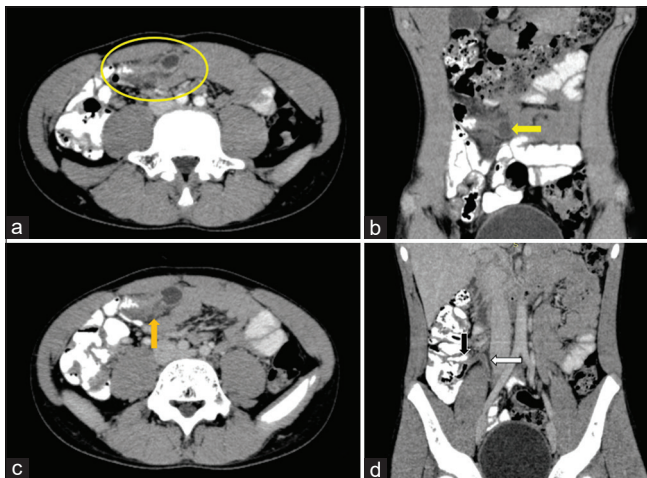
Axial and coronal reformatted images of contrast-enhanced Computed Tomography with positive oral contrast of the abdomen of the same patient show (a) an inflamed Meckel's diverticulum with surrounding fat stranding and collection at its apex (area within yellow oval), (b) the origin of the diverticulum from the antimesenteric aspect of the ileum (yellow arrow), (c) shows a focal breach in its posterior wall (orange arrow), and (d) shows a normal appendix (white arrow) and ileocecal junction (black arrow).
